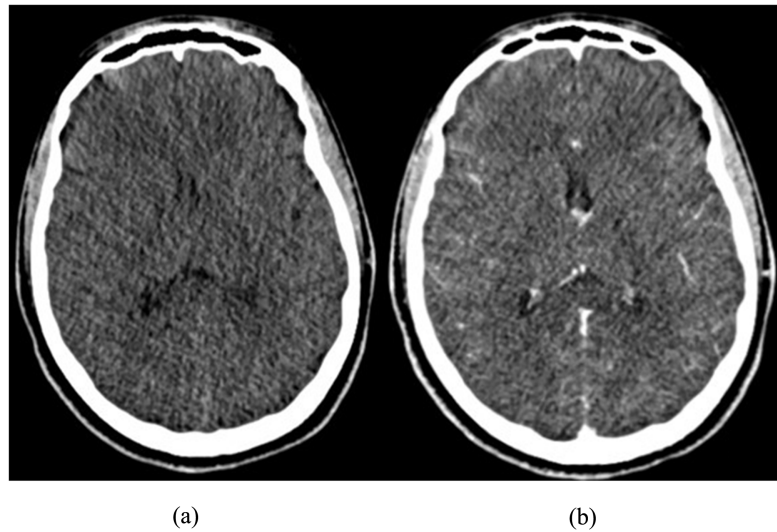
Axial section of a cerebral CT scan without injection (a) the after injection of contrast (b), showing no cerebral abnormality.
